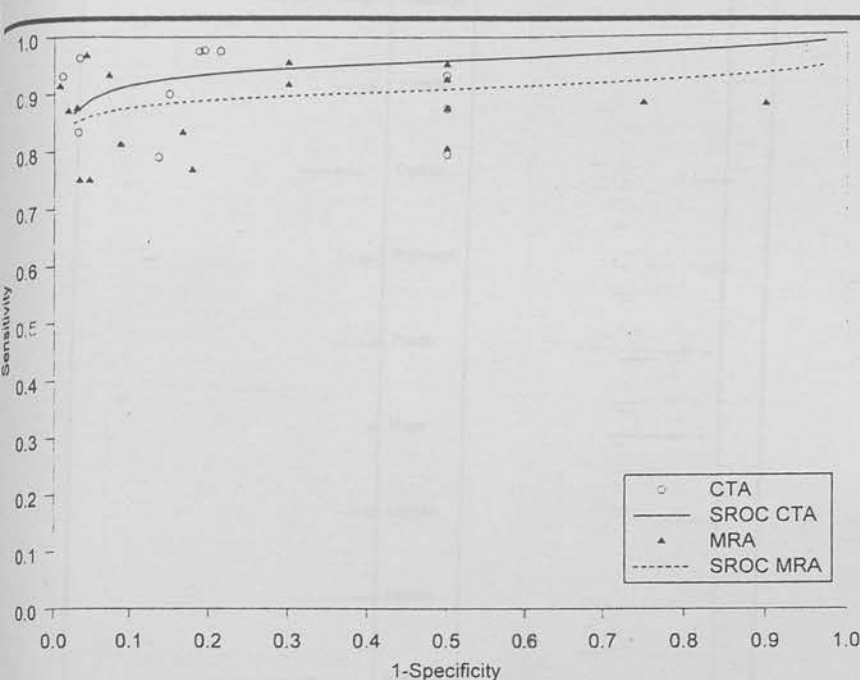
Graph of summary receiver operating characteristic (SROC) curves per subject for CT angiography (CTA) and MR angiography (MRA) compared with the reference standard, intra-arterial DSA. Both curves are concentrated in the upper left corner of the receiver operating characteristic space, with a large area under the curve. This indicates that both examinations performed well. The CT angiography curve is marginally better than the MR angiography curve, but the difference is not significant.
